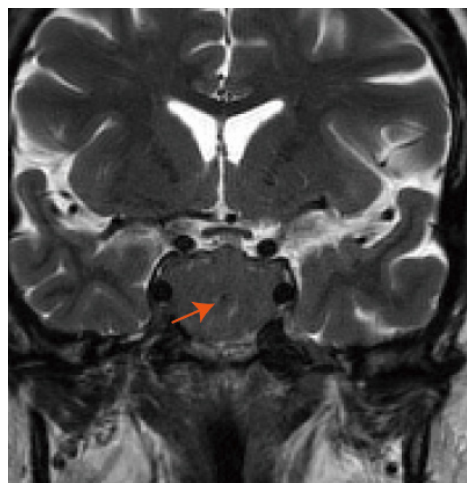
T2-weighted image shows a spotty hypointensity inside the tumor (arrow).
